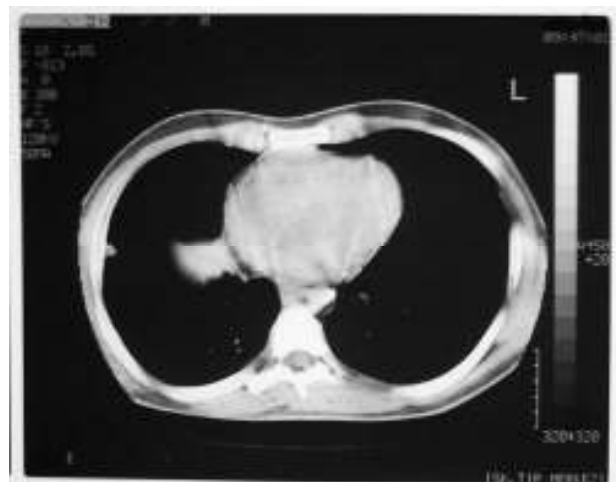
8.5 year later, chest computed tomography showed no progression in the metastases compared with the previous films.
